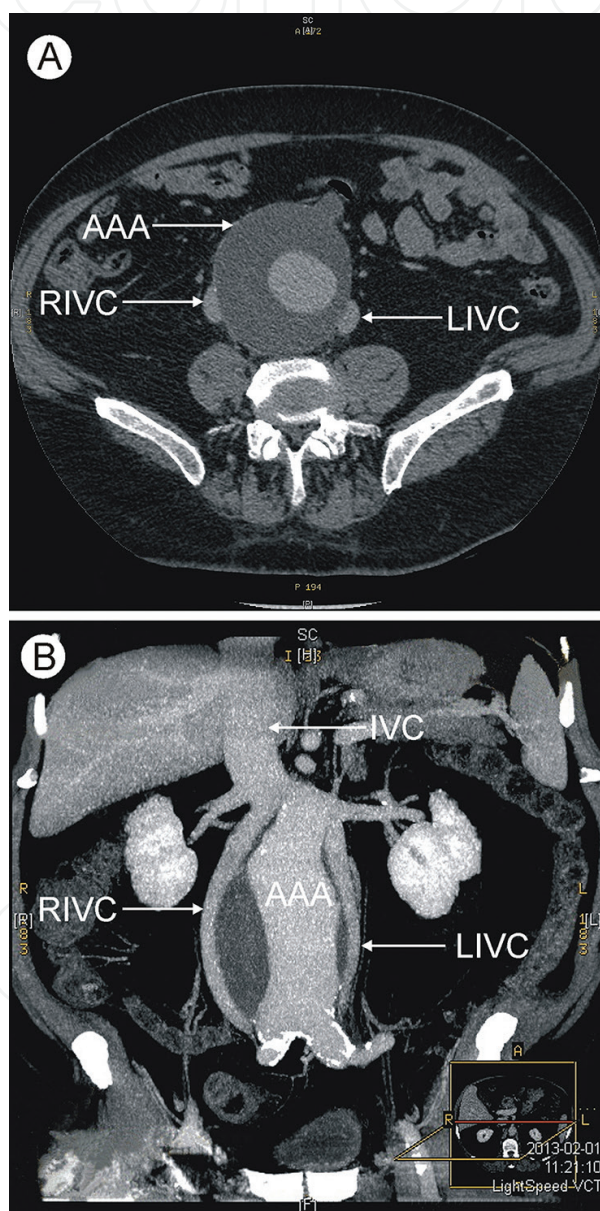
Computed tomography investigation of the abdomen with duplication of the inferior vena cava (CT-64-row MDCT scanner, Light-speed VCT, GE, Waukesha, Wisconsin, USA). (A) Transverse scan on L3 level, (B) three-dimensional computed tomography reconstruction of the vessels (posterior view). Ao: aorta, AAA: abdominal aortic aneurysm, IVC: inferior vena cava, LIVC: left inferior vena cava, RIVC: right inferior vena cava.
